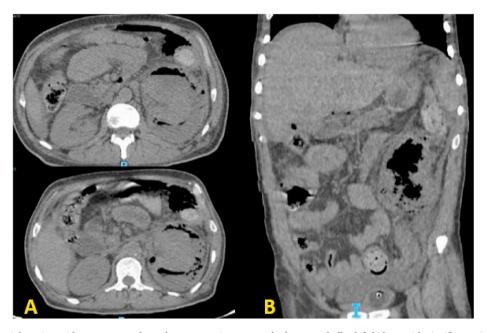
A: CT abdomen axial section without contrast: showed pneumoperitoneum and edematous bulky left kidney with significant air inside, and perinephric pneumatosis with fluid collection.
